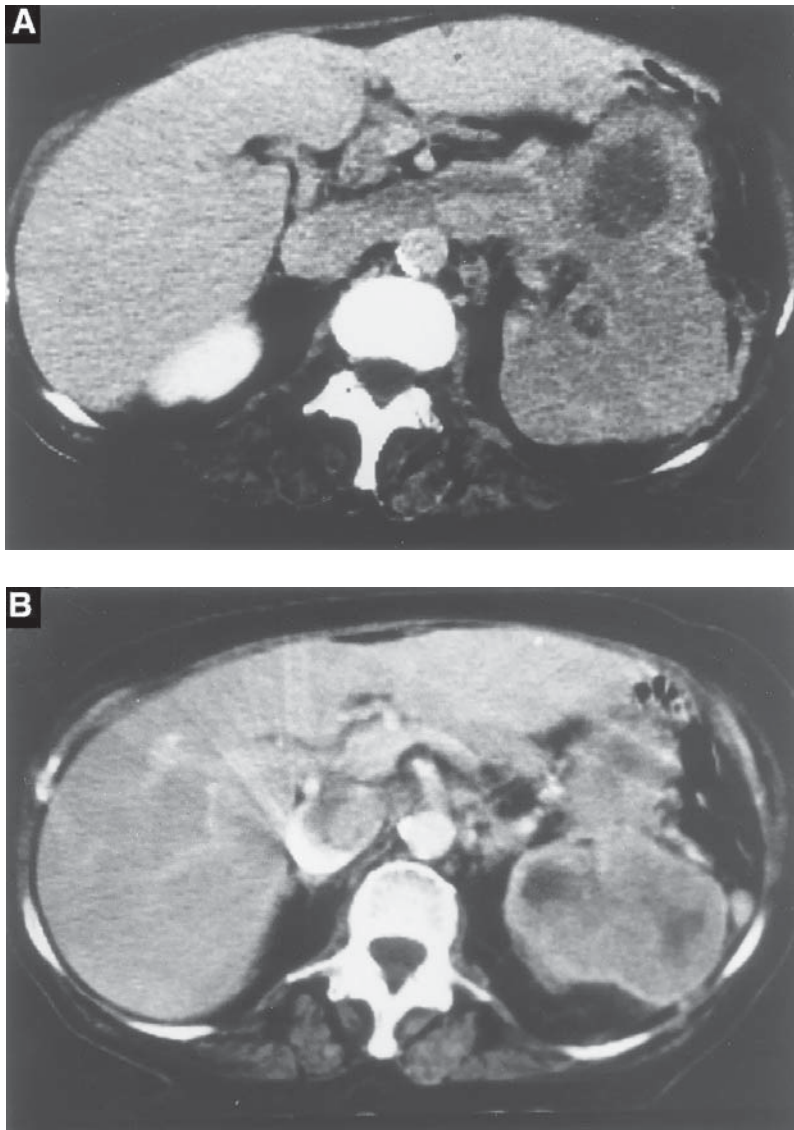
(A) CT scan (axial view) showing large left renal tumor extending through left renal vein into IVC. (B) Different image of same patient. Notice tumor in IVC with surrounding contrast.
